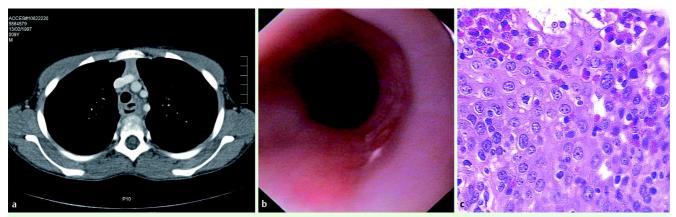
a Chest computed tomography scan showing an upper third retroesophageal perforation, with a periesophageal fluid collection (20 × 10 mm). b Esophageal endoscopy. c Biopsy showing intraepithelial eosinophil aggregates.
